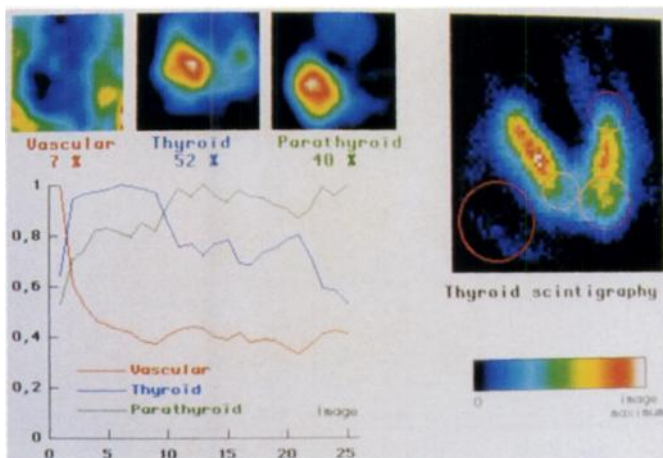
FADS results in Patient 1 (see Fig. 1). The left image is the thyroid ^{99m}Tc scintigraphy with an ROI drawn on the palpable nodules.
